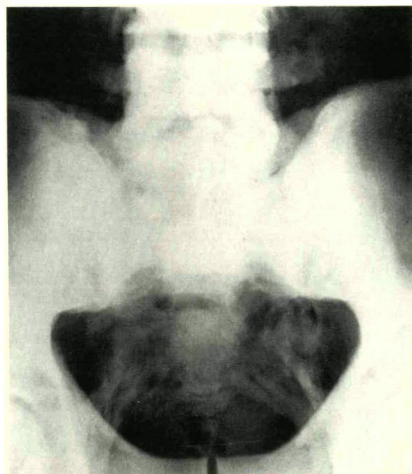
Anteroposterior radiograph of the pelvis. There is heavy calcification of the sacrospinous ligaments.
